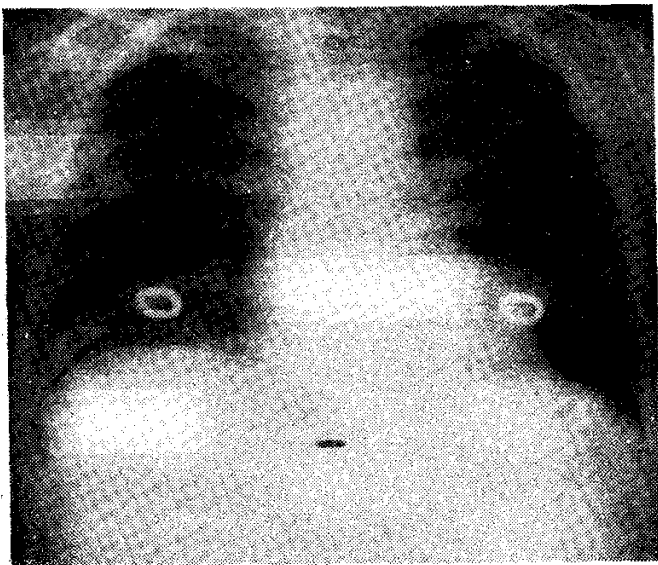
Chest roentgenogram with radiopaque markers at xiphoid (x), suprasternal notch (S) and nipples (N, N).
